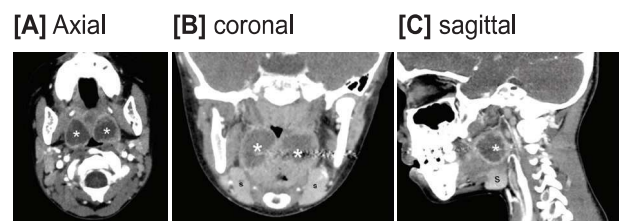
Contrast-enhanced computed tomography scan of the neck showing the bilateral, symmetric intratonsillar collections (*). S: submandibular salivary gland
